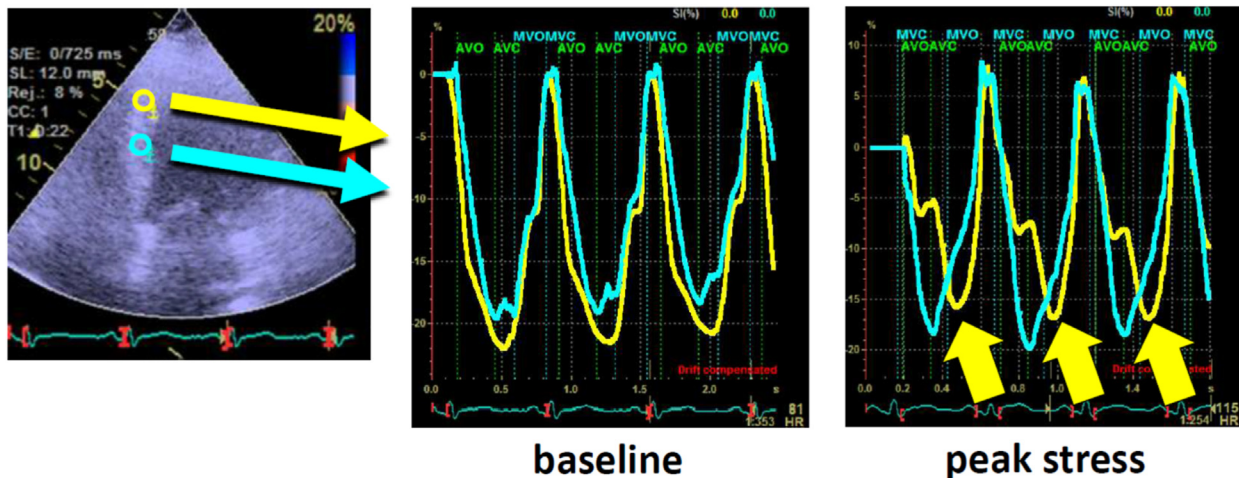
Postsystolic shortening during stress echocardiography. Tissue Doppler acquisitions taken during dobutamine stress echocardiography of the mid (turquoise curves) and distal (yellow curves) septum. At baseline, both segments show systolic shortening of normal amplitude. At peak stress, the ischemic segment (yellow) develops postsystolic shortening (yellow arrows).³ AVC, Aortic valve closure; AVO, aortic valve opening; MVC, mitral valve closure; MVO, mitral valve opening.
